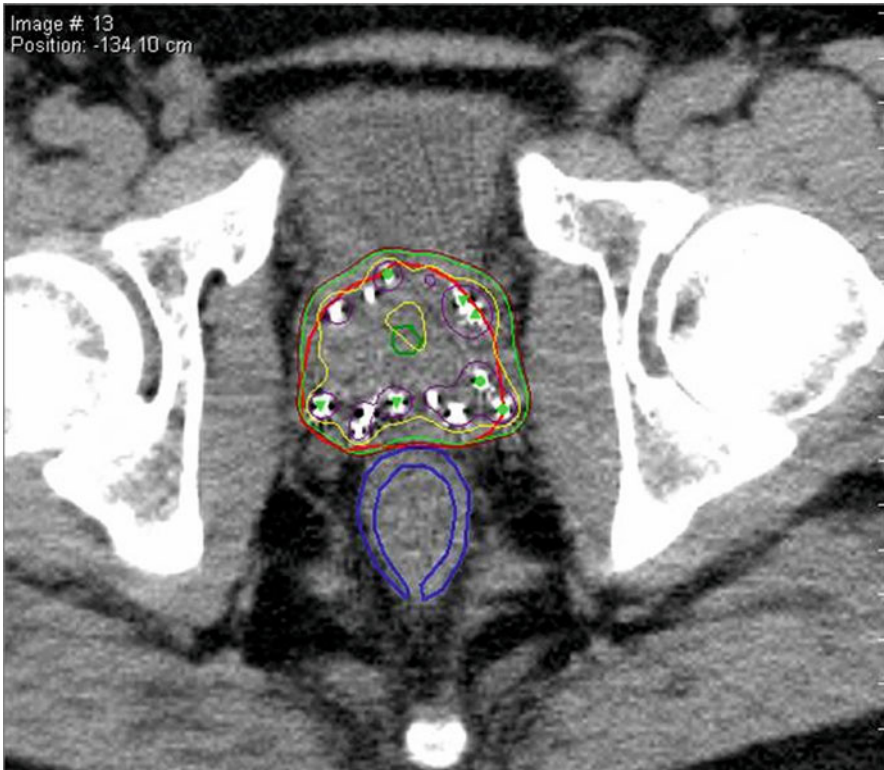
Post-implant CT for dosimetry with arbitrary delineation of nonvisualised urethra
